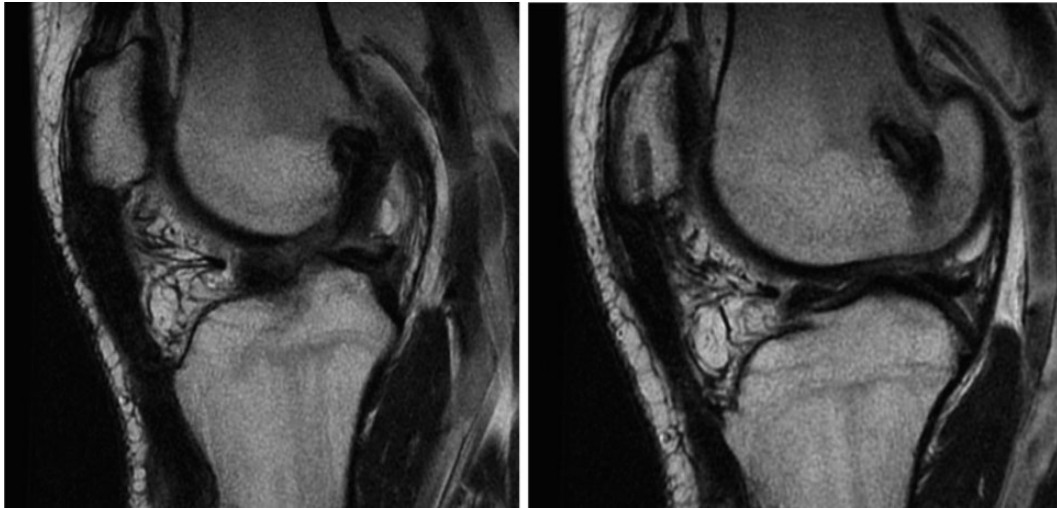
T2 magnetic resonance images 1 year postoperatively show a healed patellar tendon repair.
